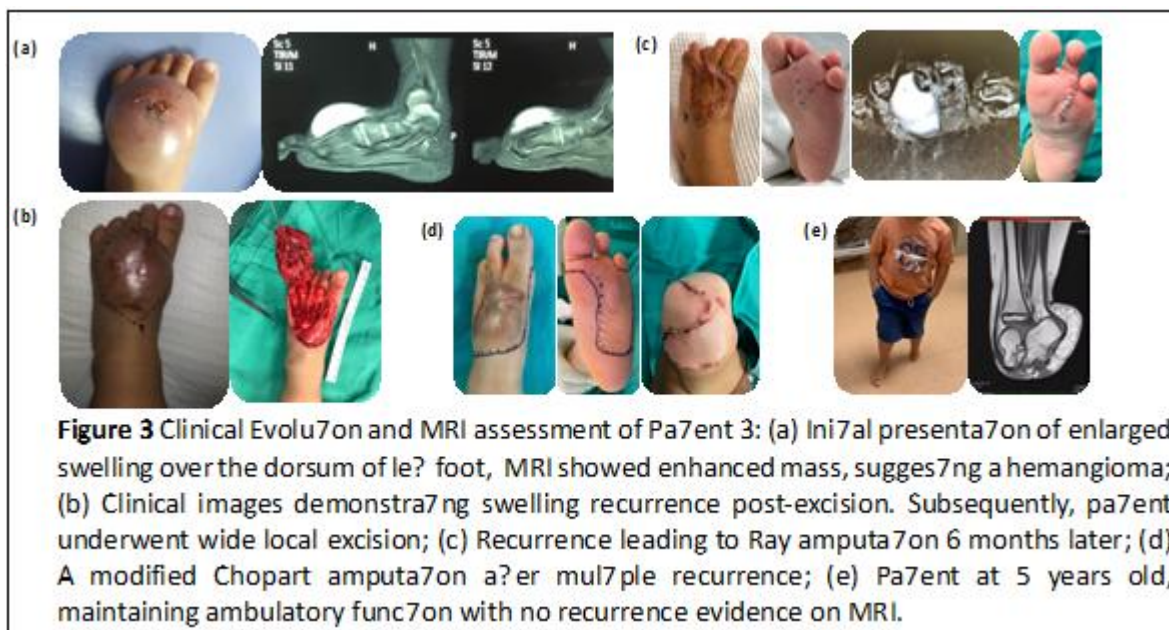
Clinical Evolution and MRI assessment of Patient 3: (a) Initial presentation of enlarged swelling over the dorsum of left foot, MRI showed enhanced mass, suggesting a hemangioma; (b) Clinical images demonstrating swelling recurrence post-excision. Subsequently, patient underwent wide local excision; (c) Recurrence leading to Ray amputation 6 months later; (d) A modified Chopart amputation after multiple recurrence; (e) Patient at 5 years old, maintaining ambulatory function with no recurrence evidence on MRI.
